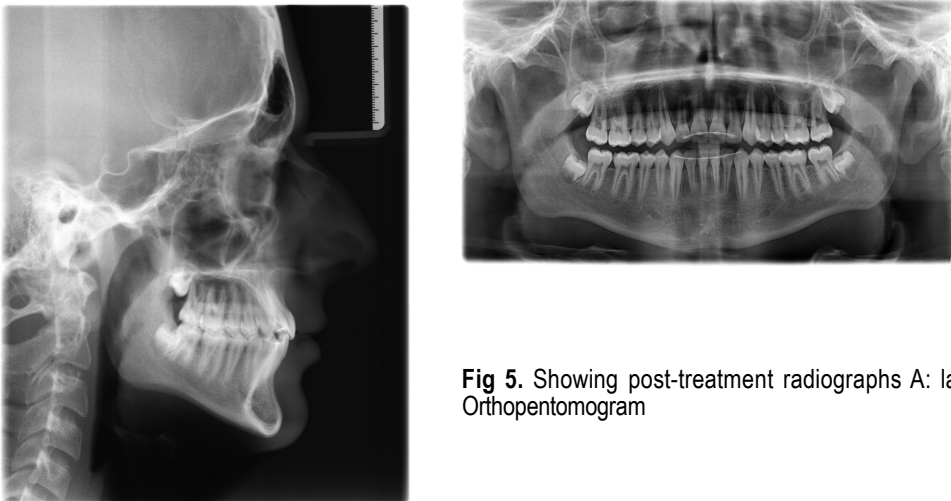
Showing post-treatment radiographs A: lateral cephalometric B: Orthopantomogram
